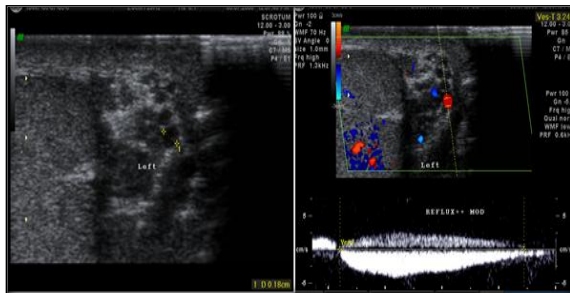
Infertile male patient of age 26 years; Gray scale image showing undilated venous plexus (0.18) cm, having moderate reflux in doppler, lasting for (>3secs) Grade II on left side during valsalva.
